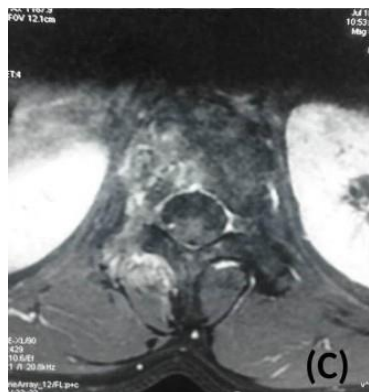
Axial MRI view showing tumor regression after neo-adjuvant chemotherapy.
